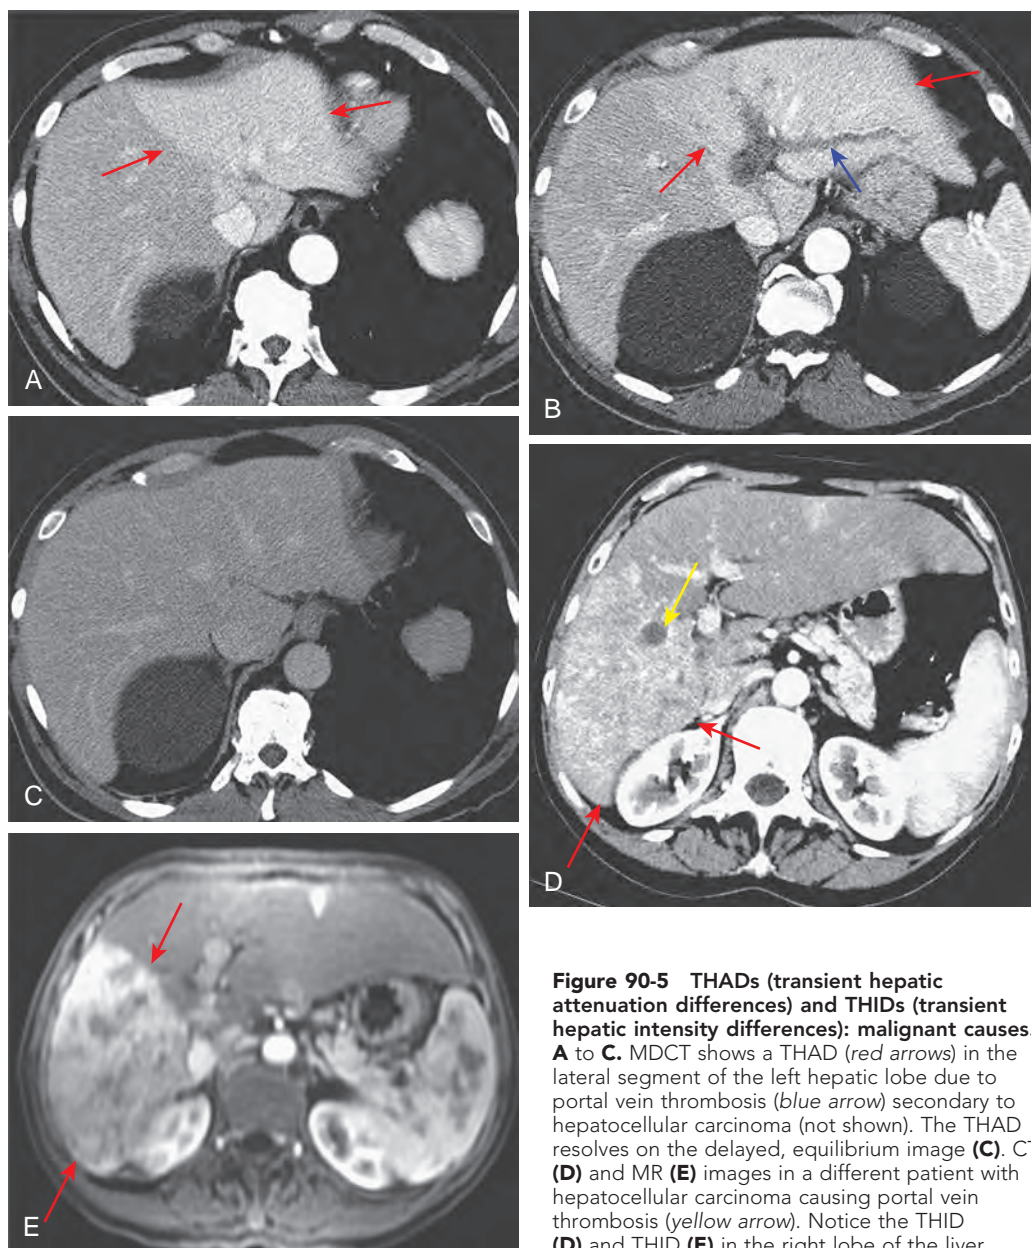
THADs (transient hepatic attenuation differences) and THIDs (transient hepatic intensity differences): malignant causes. A to C. MDCT shows a THAD (red arrows) in the lateral segment of the left hepatic lobe due to portal vein thrombosis (blue arrow) secondary to hepatocellular carcinoma (not shown). The THAD resolves on the delayed, equilibrium image (C). CT (D) and MR (E) images in a different patient with hepatocellular carcinoma causing portal vein thrombosis (yellow arrow). Notice the THID (D) and THID (E) in the right lobe of the liver.
